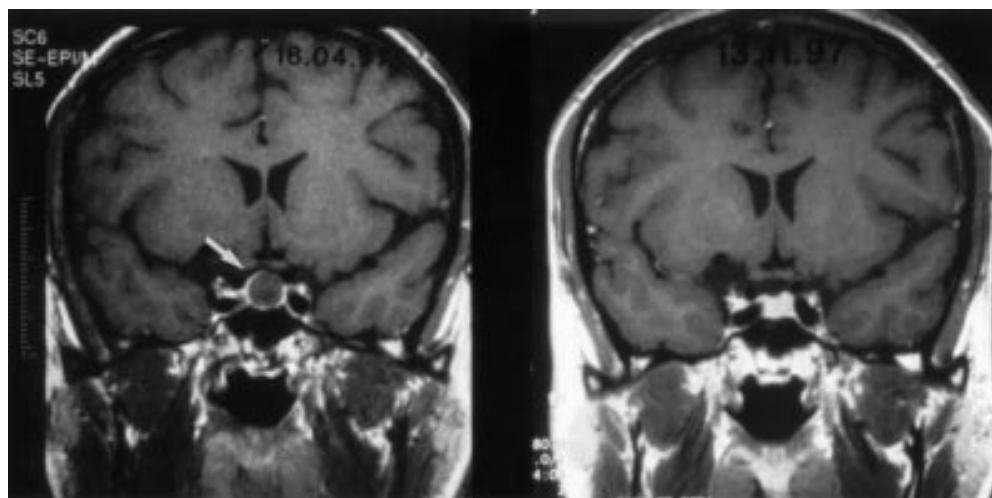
MRI scan on admission (left) and after seven months (right).
